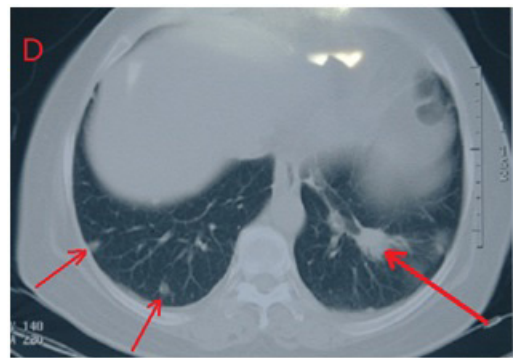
Two years late, it was found that metastasis in left lung start to grow and old small mass was bigger than two years ago in the right lung. It indicated that CDPI therapy can not only control primary mass of pancreatic cancer but also can control small metastasis grow slowly for a two years by abscapale effect which induced by CDPI to whole body immunological systemic therapy. In the general, patient with pancreatic cancer with lung metastasis, there is few to live over one year, but she live over two years in tumor stable status after CDPI therapy, it indicated that CDPI could induce the immunological response like cytokines and autologous antibodies in the research (left two arrows shows two of small mass as new metastasis and right arrow shows a small bigger mass as a old metastasis without PET/CT and pathological proved).
